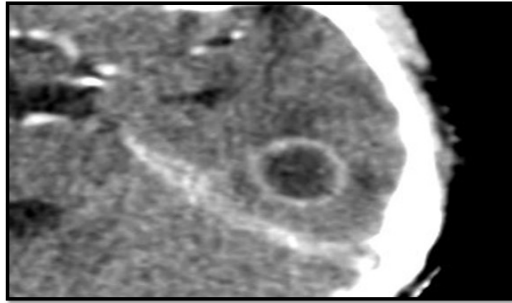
Axial section showing contrast enhanced CT brain showing abscess in left temporal lobe.
